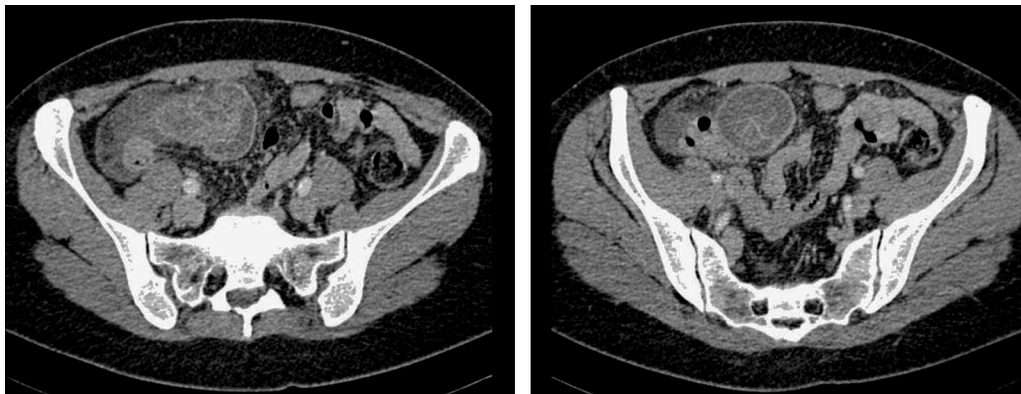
Axial slice of CT scan, showing the typical reniform and target-like patterns.
